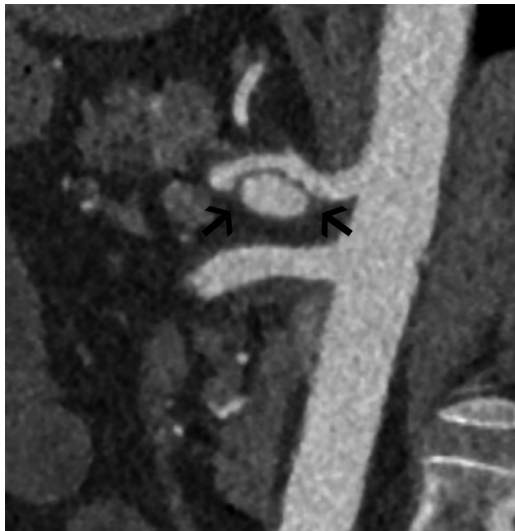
Sagittal CTA image of aorta-mesenteric artery thrombosis (thrombosis into the CA is indicated with a black arrow and thrombosis into the SMA is indicated with a white arrow).
